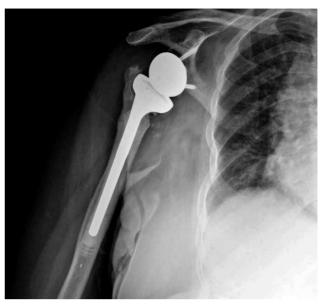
Mid-term follow-up X-ray of the patient undergoing reverse shoulder arthroplasty.
